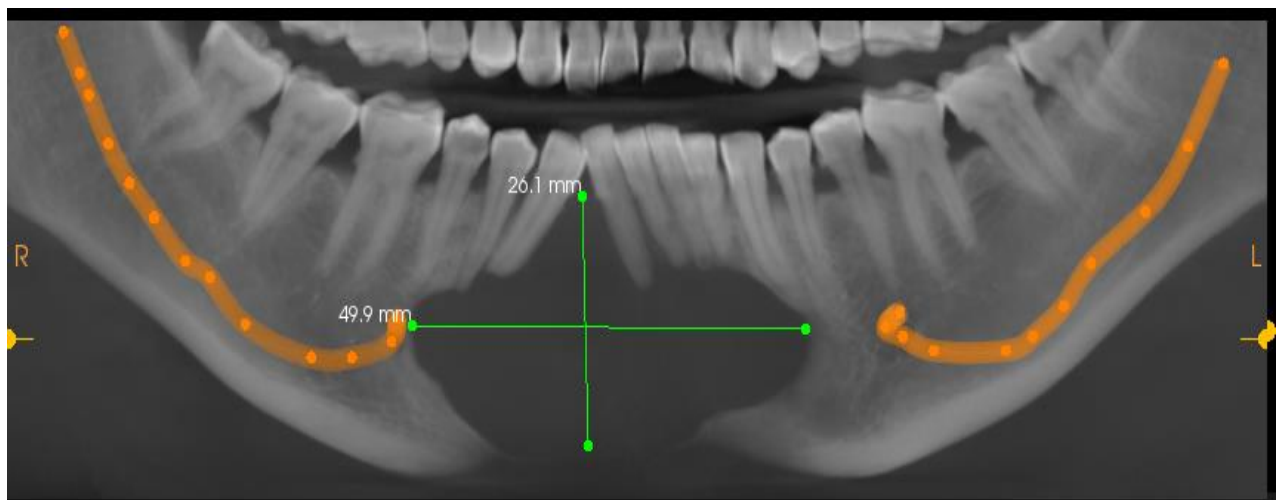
CBCT shows unilocular appearance without evidence of locularity and calcification.
